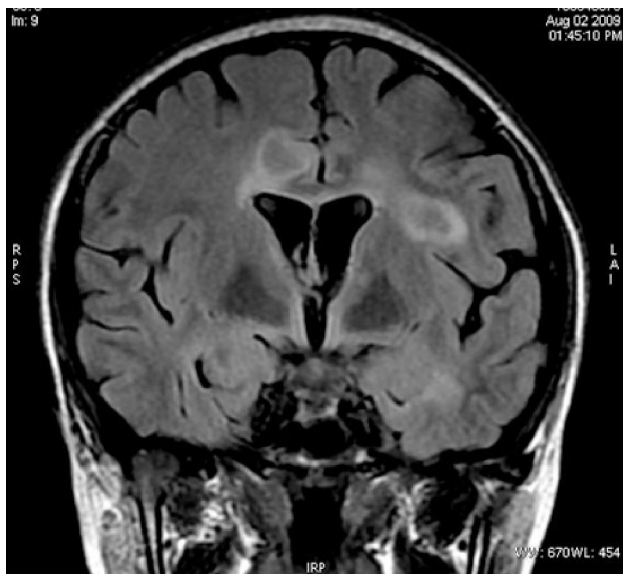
Coronal FLAIR MRI of brain showing periventricular hypointense lesions.
